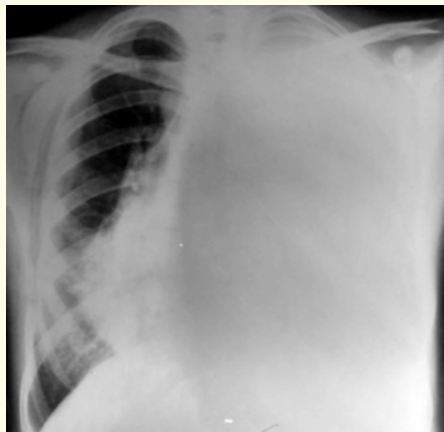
Frontal chest X-ray showing a complete opacification of the left hemithorax with mediastinal shift, consistent with total left lung opacity.
